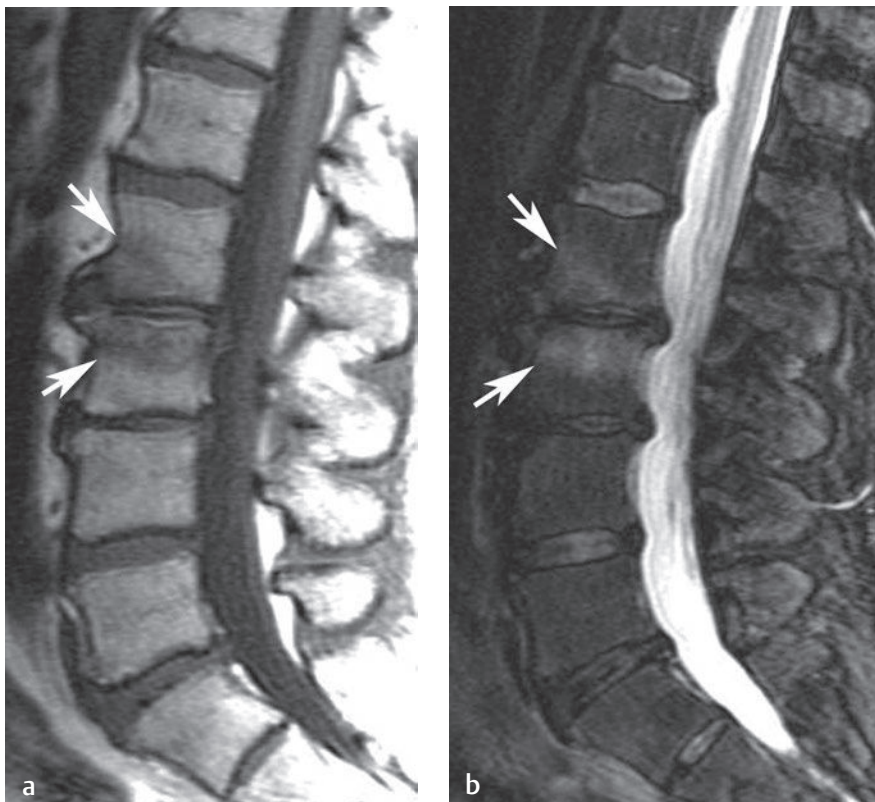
Modic type-1 (fibrovascular) changes. Sagittal (a) T1-weighted and (b) fat-suppressed T2-weighted images show, at the L2-L3 level, the typical pattern (arrow on each) of decreased signal intensity on the T1-weighted image and increased signal on the T2-weighted image that is seen with Modic type-1 end-plate changes.[†]
